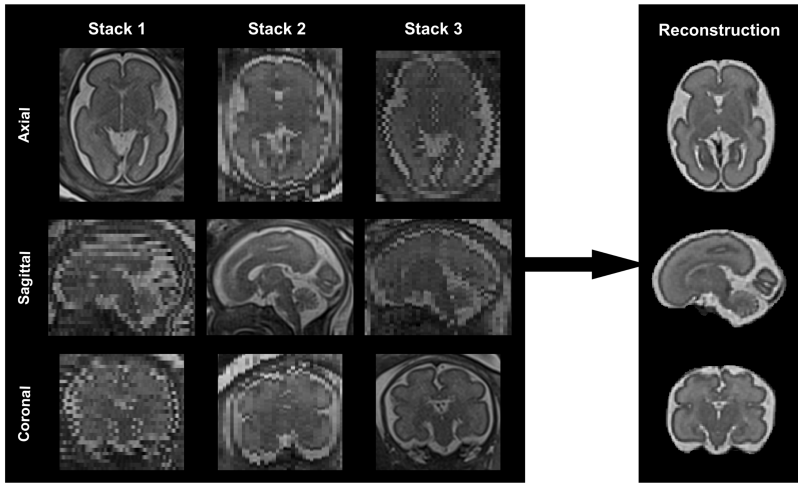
Example of reconstruction from motion-corrupted stacks of 2D MRI slices. First 3 columns (i.e., stacks 1, 2, and 3) correspond to axial, sagittal, and coronal acquisitions, respectively. Fourth column is the final reconstruction. Rows, from top to bottom, show axial, sagittal and coronal views, respectively, for each image.
